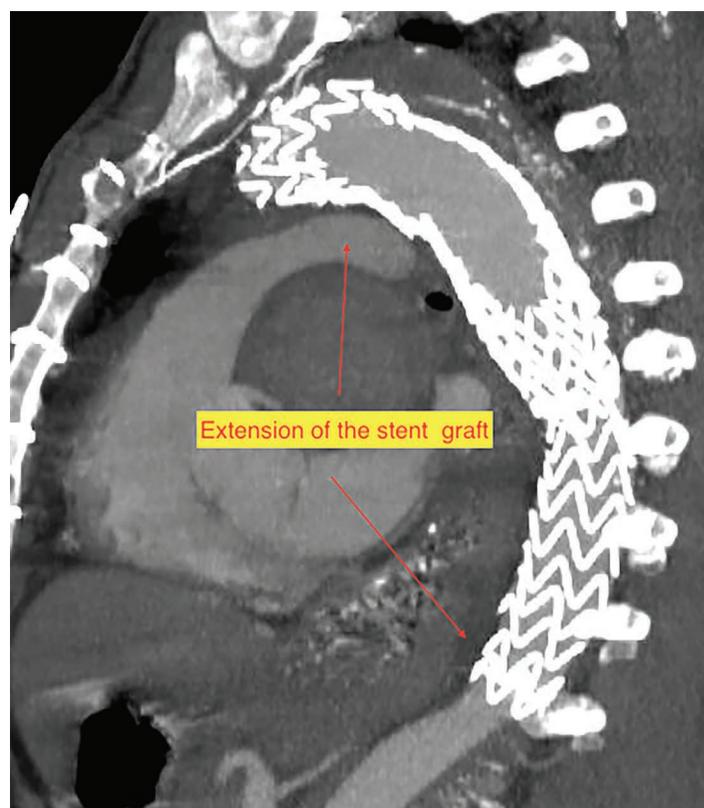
Transverse computed tomography angiography showing the stent graft extending to the diaphragm level.
